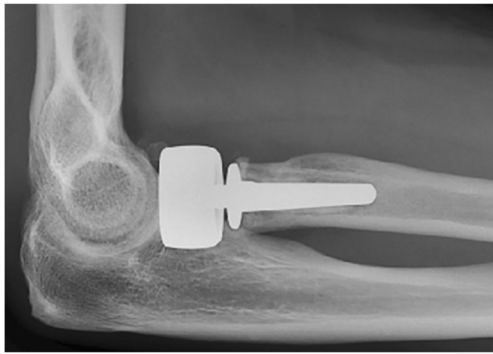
Lateral radiograph of the elbow showing a radial head prosthesis (EVOLUTIVE® Aston Medical) with periprosthetic osteolysis
